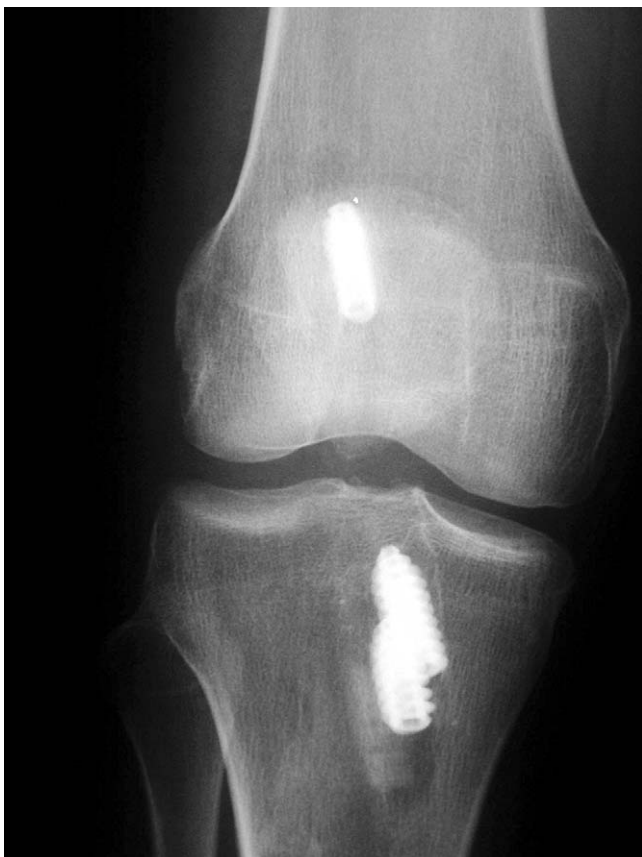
Anteroposterior radiograph depicting stacking of screws to allow for secure graft fixation in a mildly expanded tibial tunnel.
